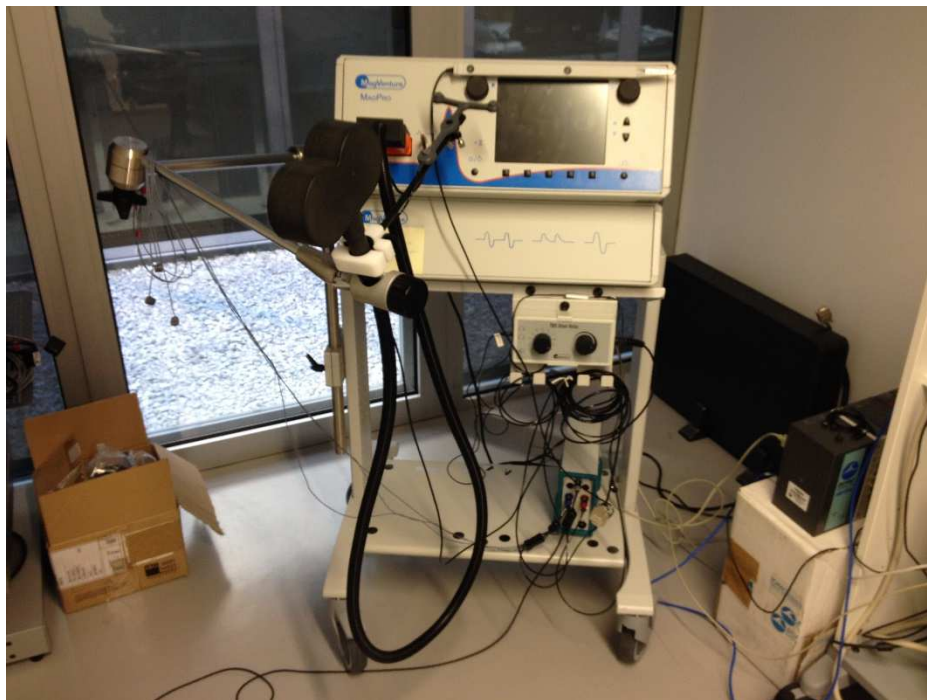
(A) Main Unit; (B) Pointer (digitizer pen); (C) Three ultrasound marker with adapter; (D) MAXX-2 with Y-shape design; (E) TMS coiler holder; (F) Triple Marker; (G) Adhesive Stickers (C. Goebel, et al. 2012. TMS Neuronavigation for CMS20 Measuring System)
